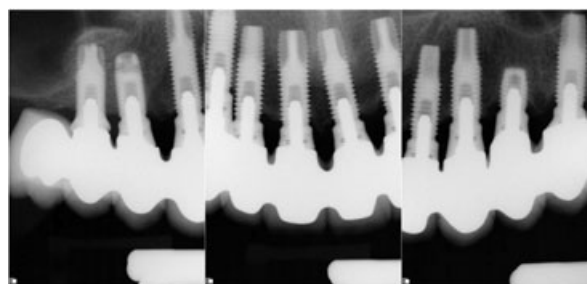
Five-year post-insertion radiographs revealed minimal crestal bone loss and excellent marginal integrity of the prosthesis.
